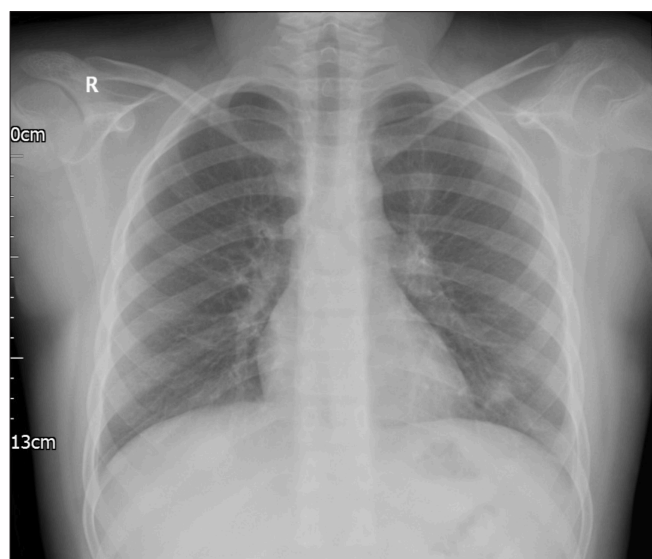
Anterior-posterior chest x-ray of a 12 year old male patient complaining of chest pain. A chest x-ray performed whilst in hospital shows an ill-defined small opacity at the left lung base suggestive of mild infection.
